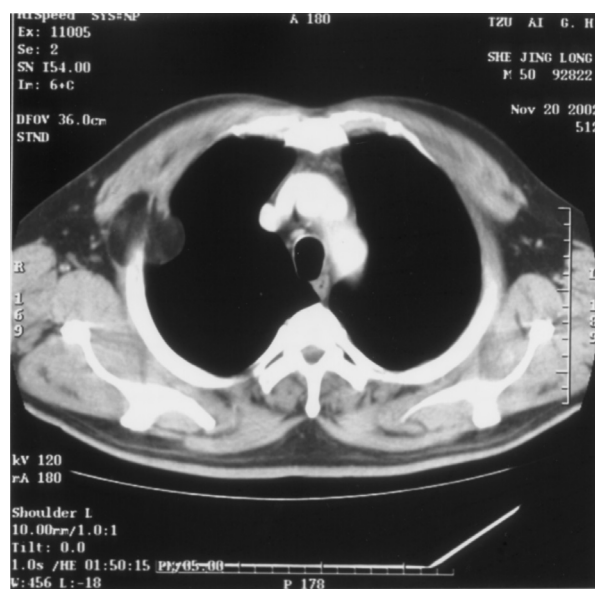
Chest computed tomography revealing a well-defined tumor straddling the intercostal space. The density of the tumor is similar to subcutaneous fatty tissue and there are focally enhanced materials within the tumor. The tumor protruded into the pleural cavity with a smooth pleural surface.
